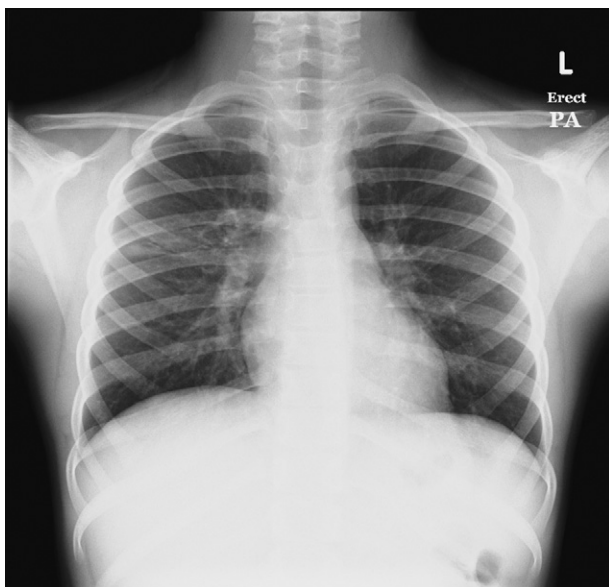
The chest radiograph 6 weeks after presentation for the patient with a right upper lobe abscess seen in Figure 1.
